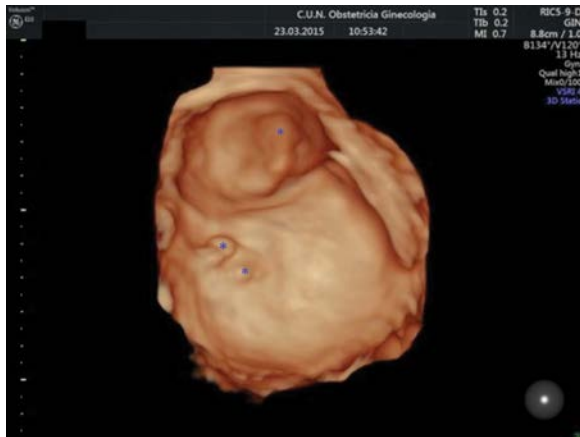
Three-dimensional ultrasound in surface rendering mode. We can observe the internal surface of a cyst's wall, depicting two locules with papillary projections (*).
